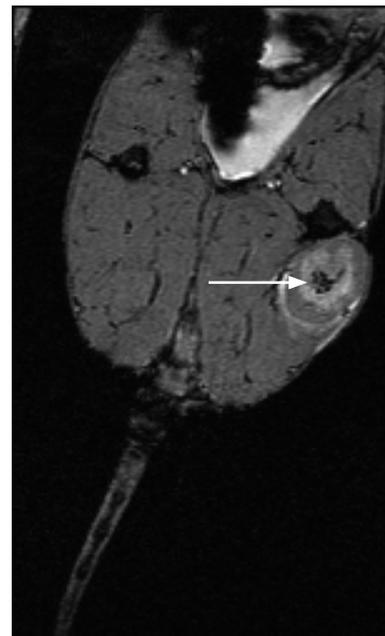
MR image one day after shock wave exposure, frontal section
